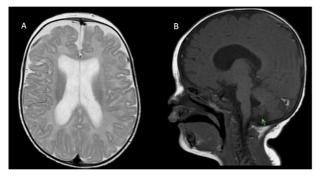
(A) Axial T2-weighted MR image shows mild to moderate ventriculomegaly without transependymal CSF resorption. (B) Sagittal T1-weighted MR images show severely hypoplastic inferior vermis.
